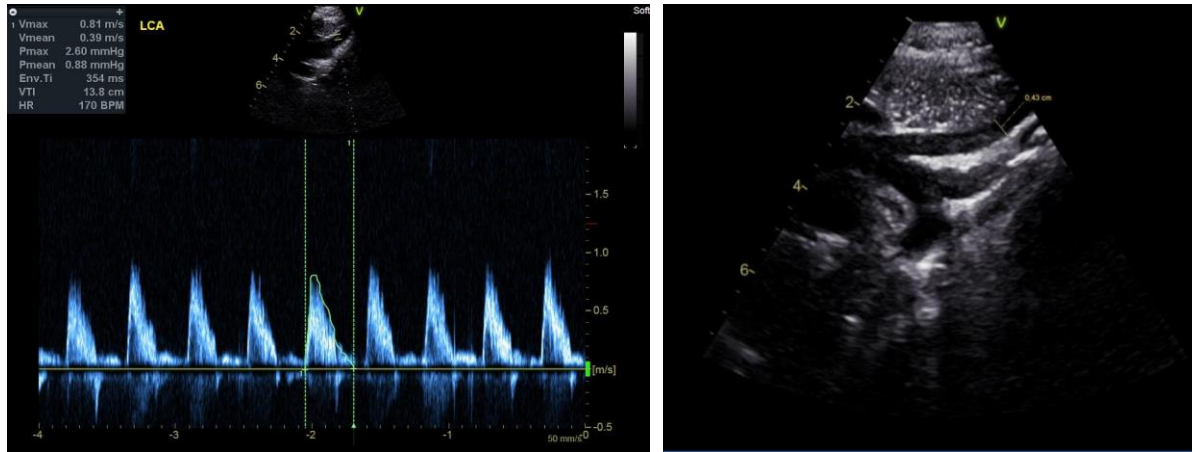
Left Common Carotid echocardiography results from a pre-intervention investigation only as a post-intervention measurement was not possible.
